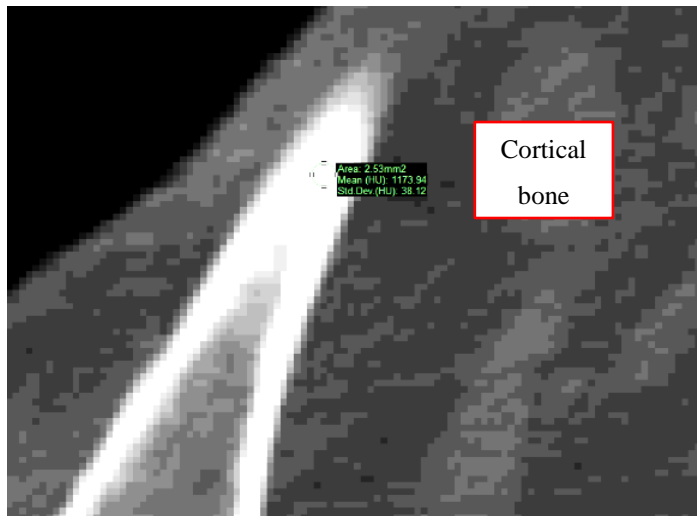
HU value reading from cortical bone in one CT slice for calibration step.
